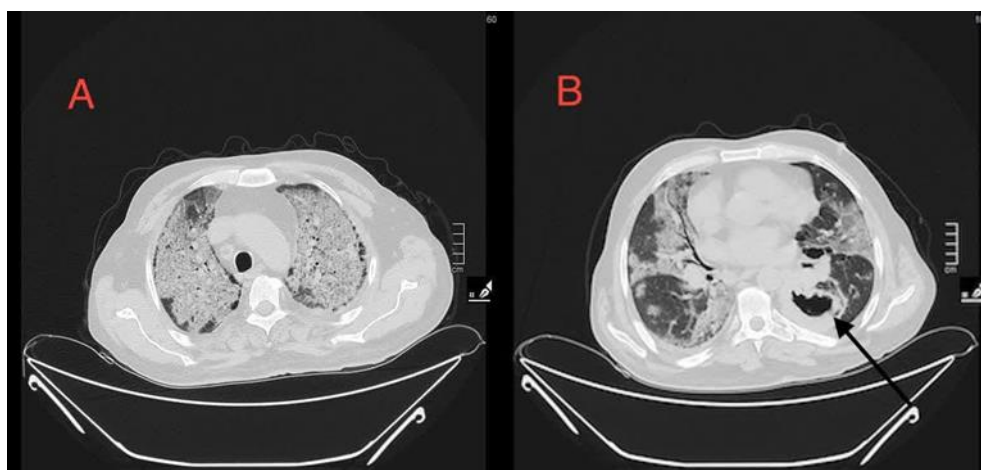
A chest CT scan of a 56-year-old man with lung cancer and a COVID-19 infection. There are extensive bilateral consolidations on top of smoking-related pulmonary interstitial disease (A and B). In addition, a cavitating mass is noted at the superior segment of the left lower lobe (arrow), in keeping with the primary lung cancer
